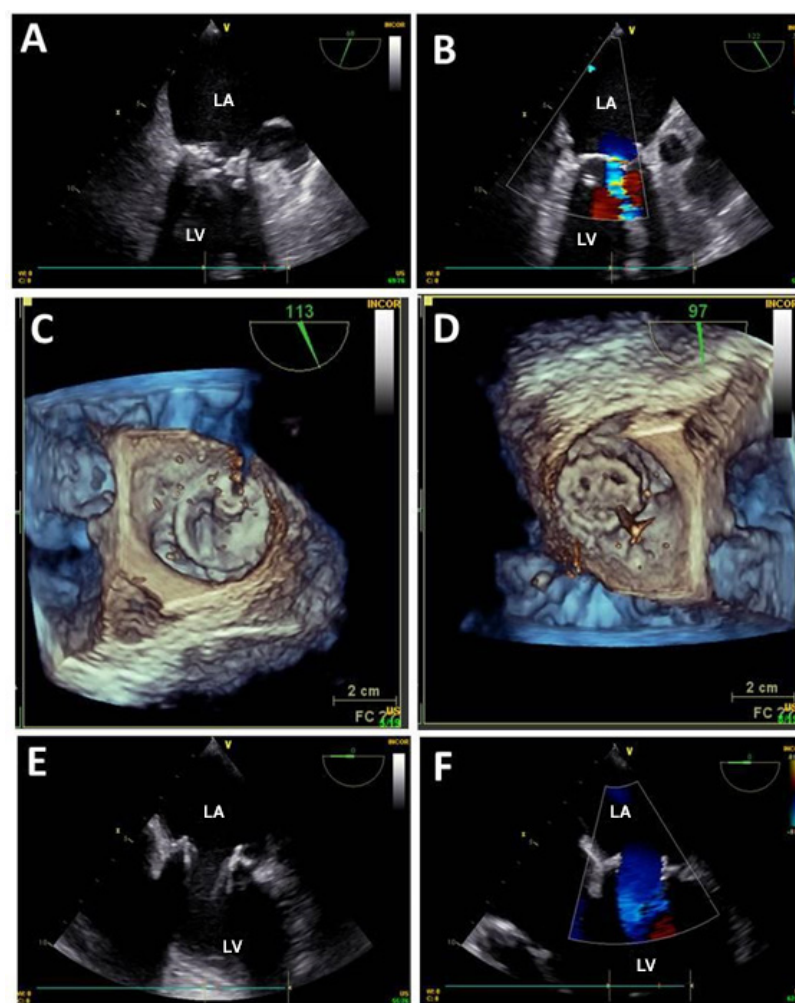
Sequence of transesophageal echocardiography images during implantation of percutaneous valve endoprosthesis. (A) Accentuated calcification of the mitral biological prosthesis; (B) Color Doppler showing acceleration of the flow through the prosthesis; (C) three-dimensional echocardiography showing severe thickening of the mitral prosthesis (atrial view); (D) guidewire going through the prosthesis; (E) endoprosthesis in normal position with normal mobility and opening; (F) normal hemodynamic profile, with laminar flow through the endoprosthesis on color Doppler. LA: left atrium; LV: left ventricle.
